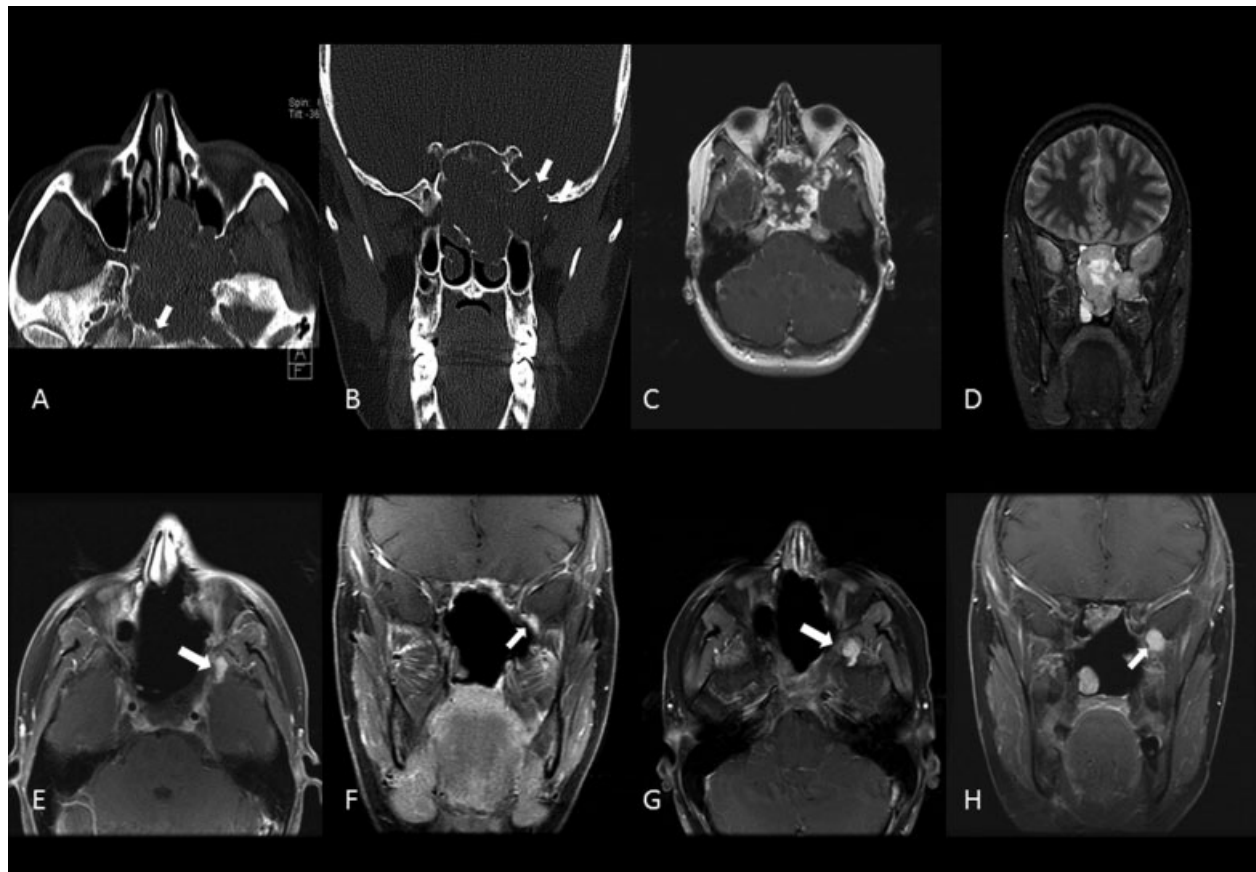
Case 1. Preoperative axial (B) and coronal (B) CT scans identify this destructive central skull base mass. There is erosion of the clivus (arrow in A) and of the middle fossa floor (arrow in B). Preoperative pos-contrast axial T1-weighted MRI (C) and coronal T2-weighted MRI (D) reveal findings typical for most “chondroid” tumors. Low signal intensity with homogeneous enhancement on T1-weighted postcontrast imaging and high signal intensity on T2-weighted imaging. Images (E) and (F) identify residual disease following the patient first surgery (arrows). Follow-up MRI imaging (G) and (H) reveal progressive enlargement of the residual tumor (arrows) prompting further surgical management.
